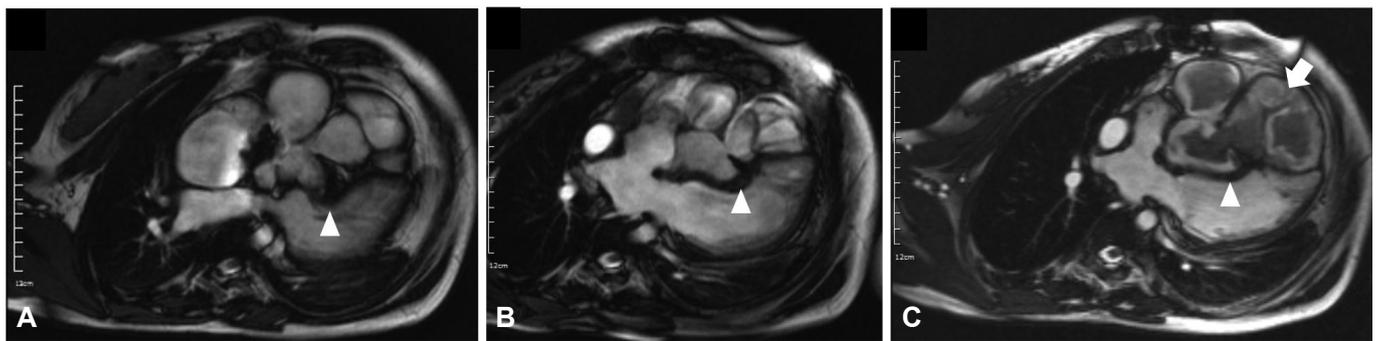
Cardiac magnetic resonance imaging. (A) Before operation, right ventricle (RV) is enlarged, compressing left ventricle (LV). Interventricular septum (arrowhead) is deviated toward LV. (B) 1 month after operation, RV size is decreased. Interventricular septum (arrowhead) is still deviated toward LV. (C) 3 years after operation, RV is filled with thrombus (arrow) without inflow. LV function is improved with decreased paradoxical septal movement (arrowhead).
